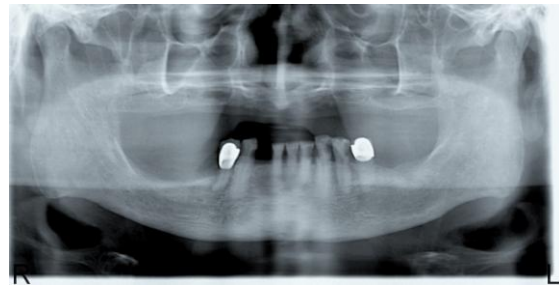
Pre-op panoramic radiograph
